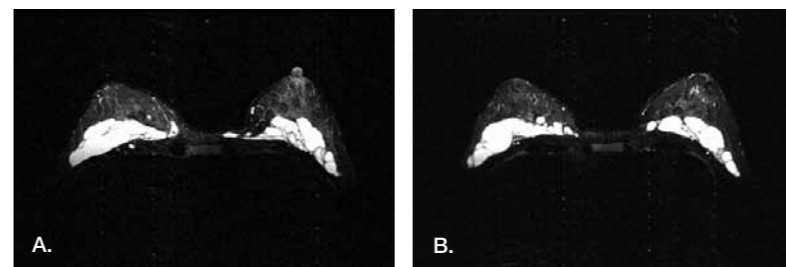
MRI scans performed at 3 months (A) and 12 months (B) following implantation of HA gel (both scans are transverse STIR sequences from the same patient).
